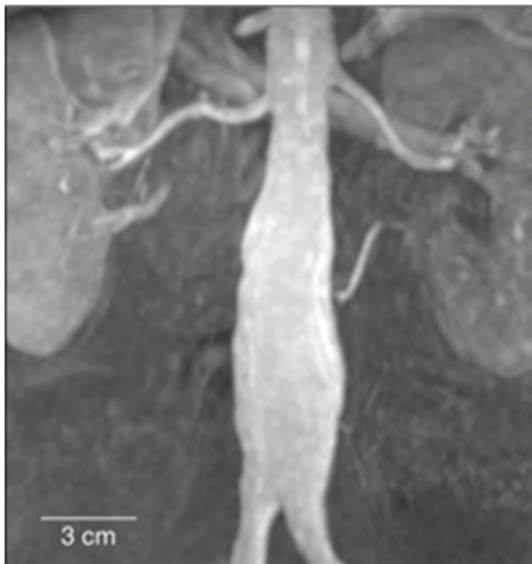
Abdominal CT revealed aortic aneurysm.
